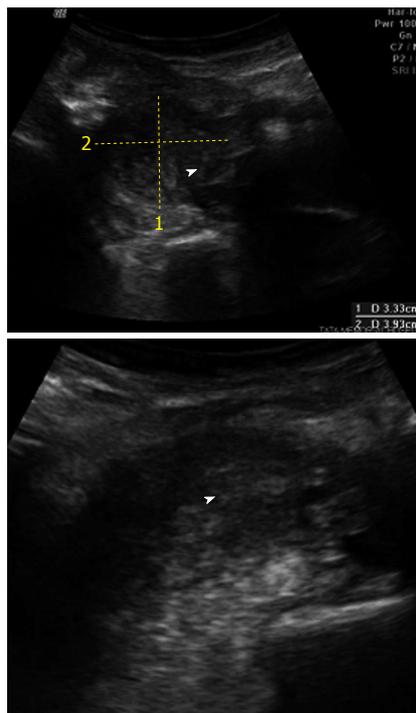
Ultrasound of the abdomen demonstrating a bulky right psoas muscle with heterogenous echotexture.
